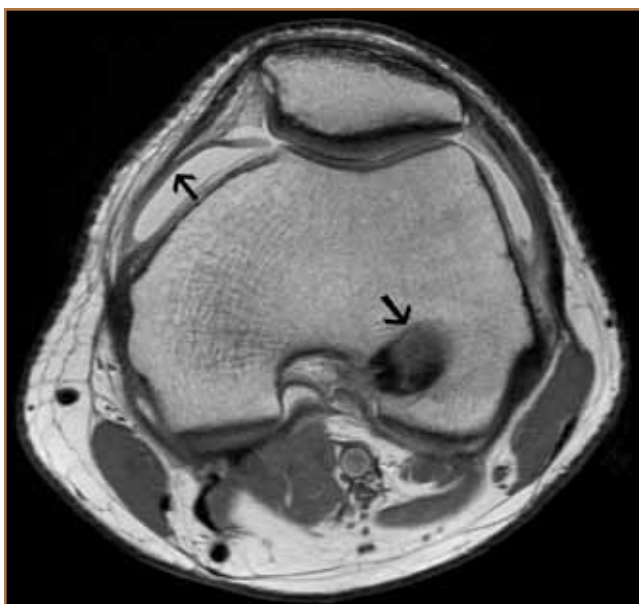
Axial fast spin echo MRI demonstrates diffuse nonspecific thickening of the synovial lining (arrow) and a fine proliferative inflammatory synovial response. There is mild resorption of bone along the femoral tunnel (arrow).
